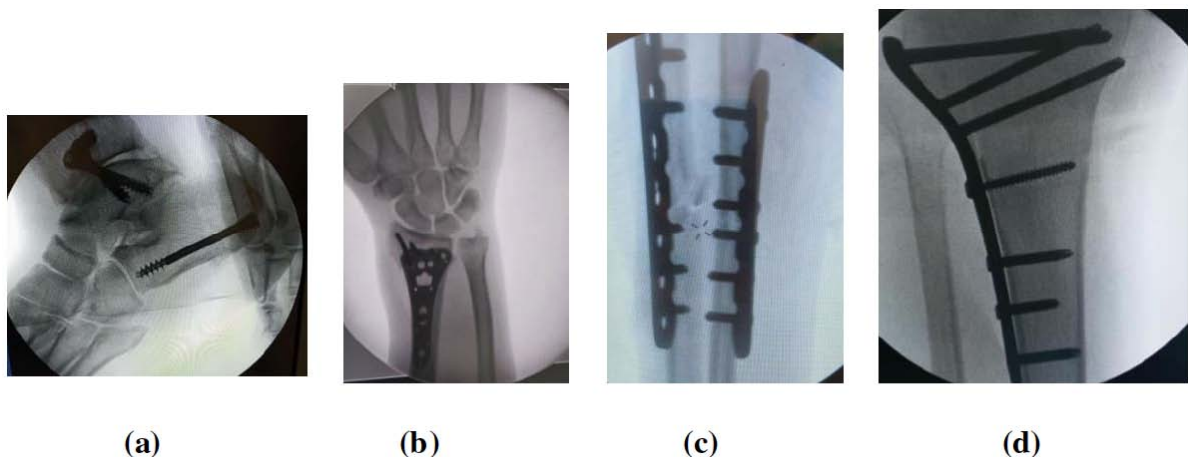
X-Ray imaging of ORIF fixations at (a) subtalar intramedullary nail (b) distal radius plate (c) midshaft radius and ulna plates and (d) proximal-distal tibia using titanium implants.
